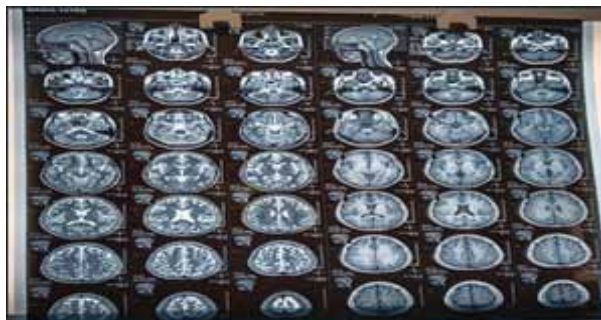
Contrast and non-contrast MRI of brain: symmetrical T1 & T2 hyperintensity areas in both dentate nuclei, basal ganglia and both thalami, suggestive of Fahr's disease.
